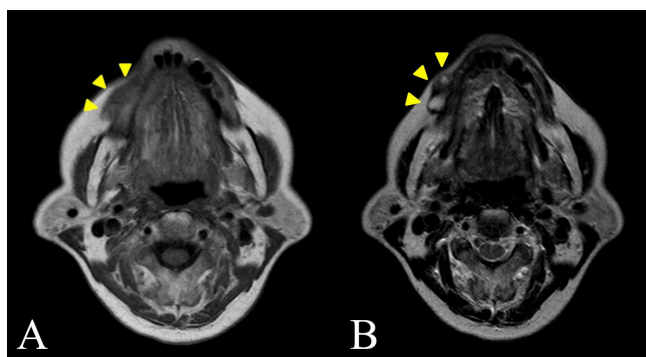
A: Magnetic resonance imaging showed the lesion (arrow head) showed a well-defined low signal intensity area on T1WI. B: There is a low signal intensity on mesial side of the lesion, and the distal side showed a high signal intensity on T2WI (arrow head).
